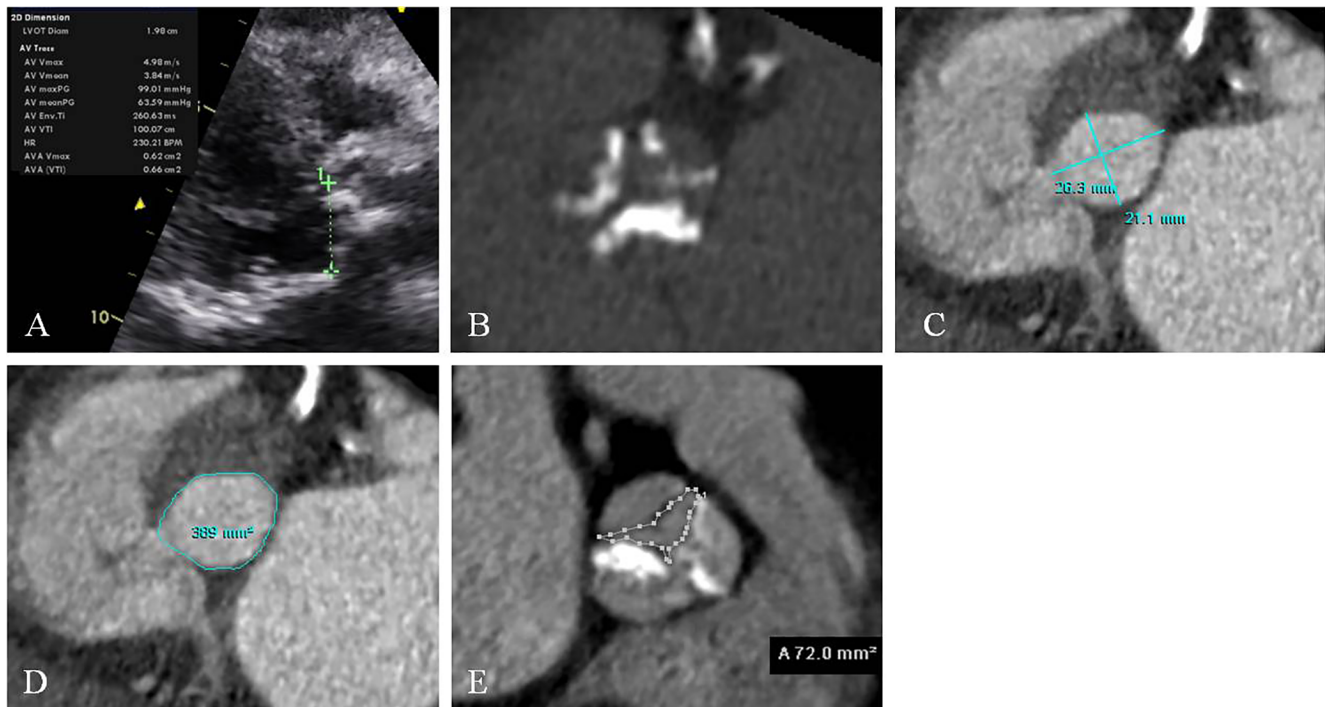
Images for a 68-year-old woman with severe aortic stenosis. Ejection fraction was 59%. *Panel A.* On transthoracic echocardiography, left ventricular outflow tract (LVOT) diameter was measured as 1.98 cm and LVOT area was calculated as 3.10 cm². Aortic valve area (AVA) was measured as 0.66 cm² by using the continuity equation. *Panel B.* Severe degree of aortic valve calcification on pre-contrast cardiac computed tomography (CCT) image. Agatston aortic valve score was 2,101. *Panel C.* The LVOT was elliptical on multiplanar reformatted CCT with an eccentricity index of 0.80 measured as the ratio of the minimum (2.11 cm)/maximum diameter (2.63 cm). *Panel D.* The measured LVOT area was 3.89 cm². *Panel E.* CCT planimetry AVA was 0.72 cm².
